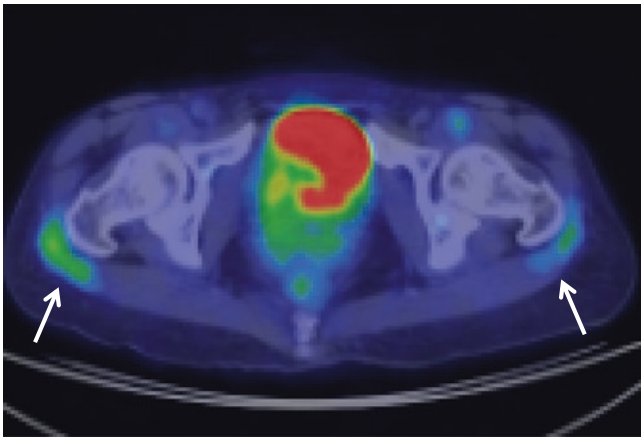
PET/CT fusion image showed increased FDG uptakes in the bilateral gluteus maximus muscles (SUV_{max} : 2.1–2.8) (arrow)
